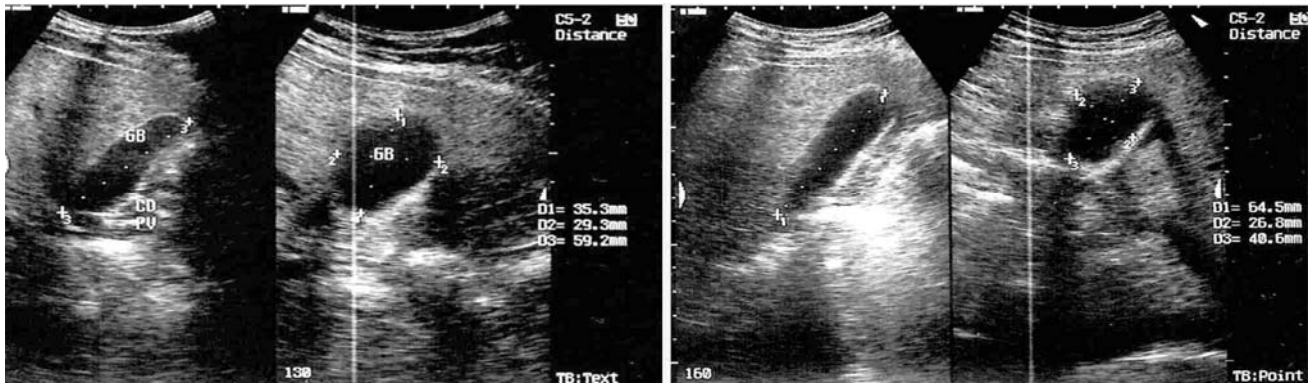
Ultrasonogram of the gall bladder in two perpendicular plans (A: sagittal and B: transverse) for a patients after surgery, showing inadequate contraction (EF=14.5 %)
